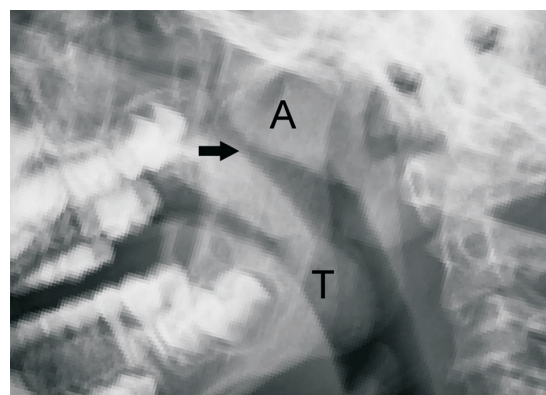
Plain radiograph of the lateral neck in a child with sleep-disordered breathing (SDB). Adenoidal (A) and tonsillar (T) hypertrophy are the most frequent findings in children with SDB. The hypertrophic adenoid can narrow the nasopharyngeal airway (arrow).
